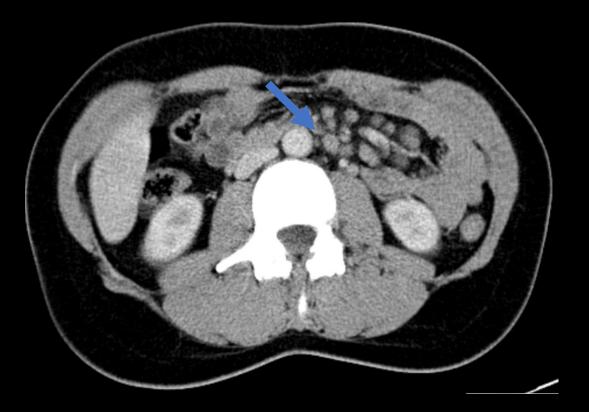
Axial CT enhanced scan. Multiple mesenteric and latero aortic enlarged lymph nodes.
